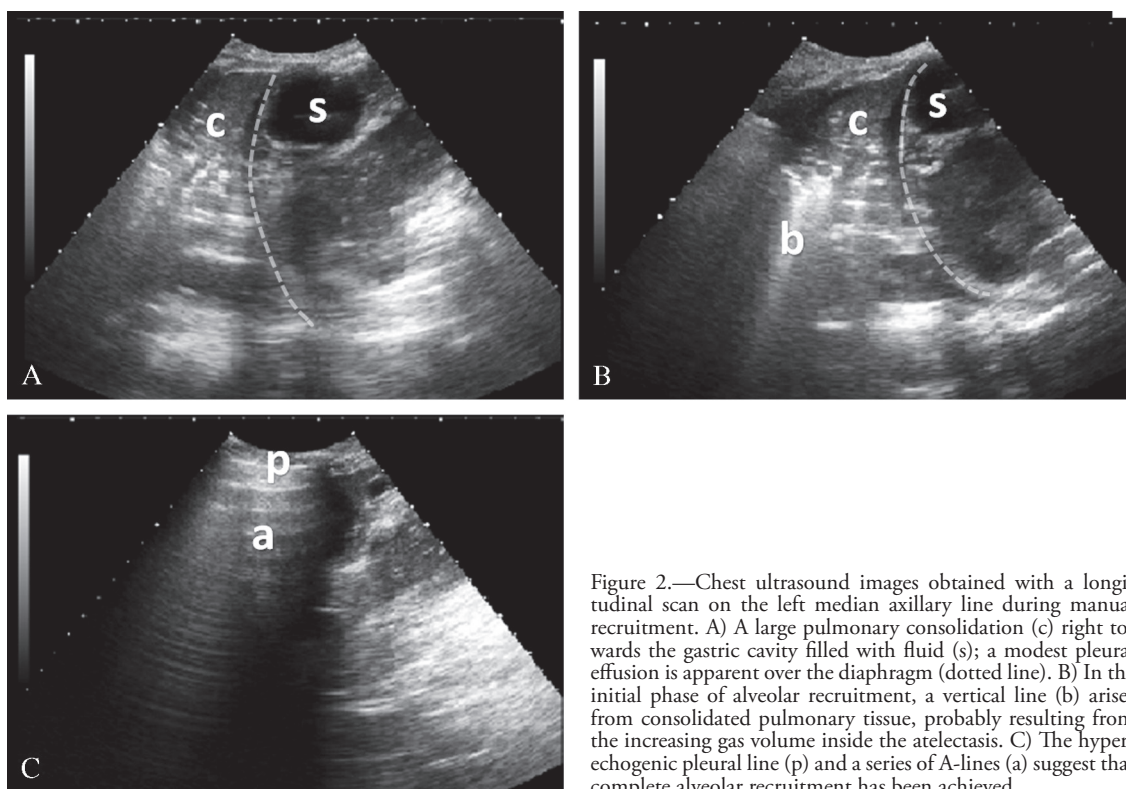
Chest ultrasound images obtained with a longitudinal scan on the left median axillary line during manual recruitment. A) A large pulmonary consolidation (c) right towards the gastric cavity filled with fluid (s); a modest pleural effusion is apparent over the diaphragm (dotted line). B) In the initial phase of alveolar recruitment, a vertical line (b) arises from consolidated pulmonary tissue, probably resulting from the increasing gas volume inside the atelectasis. C) The hyper-echogenic pleural line (p) and a series of A-lines (a) suggest that complete alveolar recruitment has been achieved.
